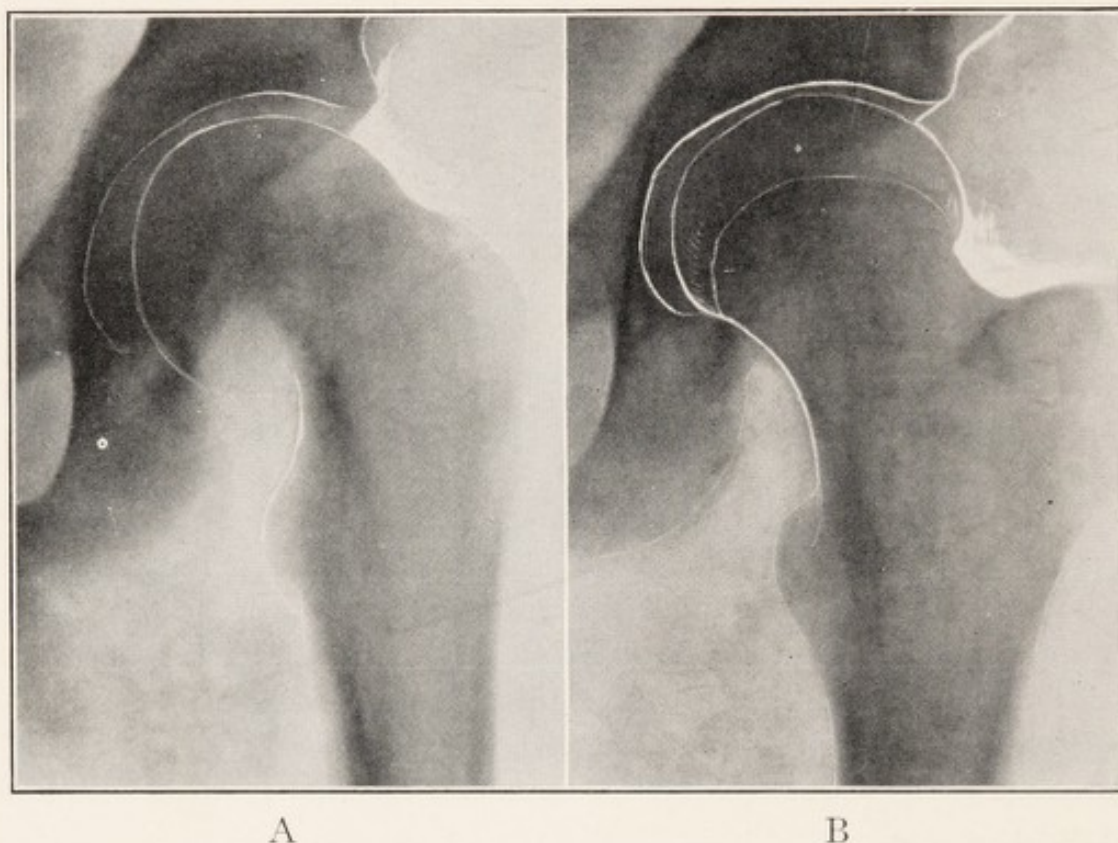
X-RAY SHOWING COXA VARA WITH DOWNWARD DISPLACEMENT OF HEAD ON NECK OF FEMUR.
